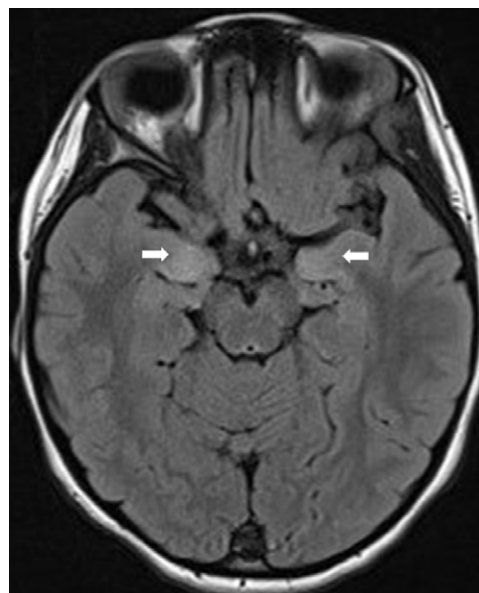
Axial FLAIR brain MRI (TR 9890, TE 90) demonstrating bilateral asymmetric (right > left) hyperintense signal abnormalities (arrows) within the uncus and adjacent parahippocampal gyri 3 months after presentation, which improved 9 months later and resolved 2 years after presentation.
